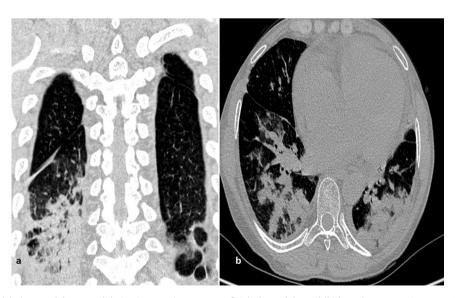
HRCT shows (a) air space lobar consolidation in posterior segment of right lower lobe and (b) bronchopneumonia pattern in both lower lobes.
